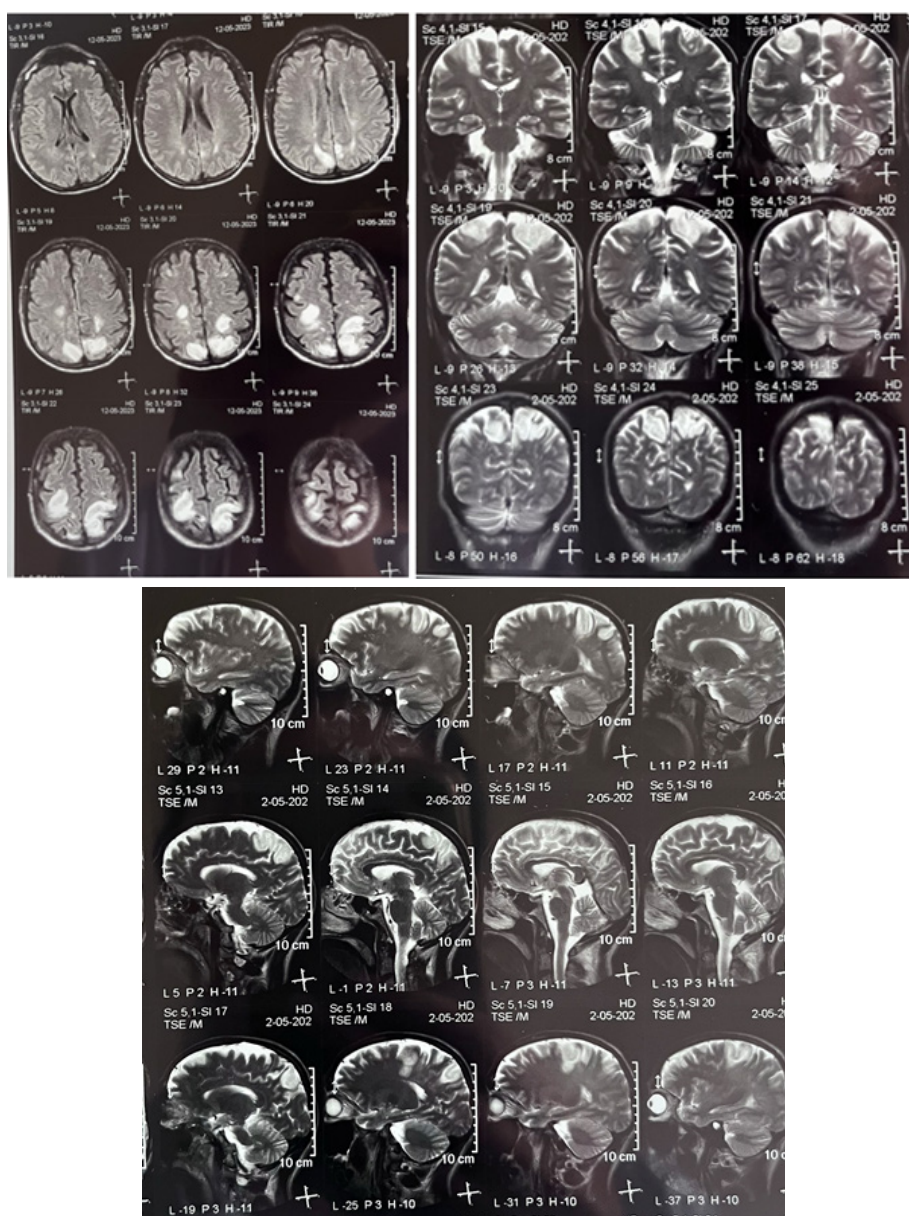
MRI of the brain.
